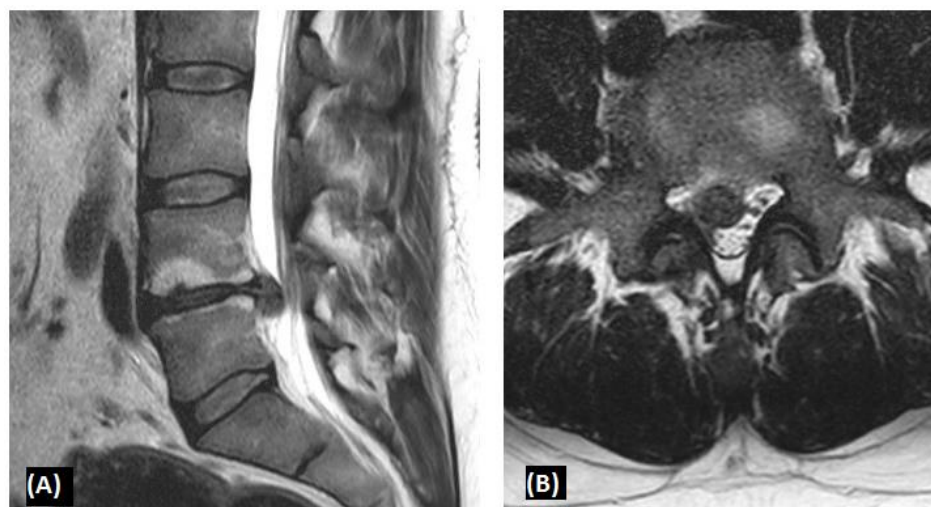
Without-Contrast T2-weighted pre-operative MR images in a 49 -year-old man, who presented with low back pain, right leg pain and neurogenic claudication
